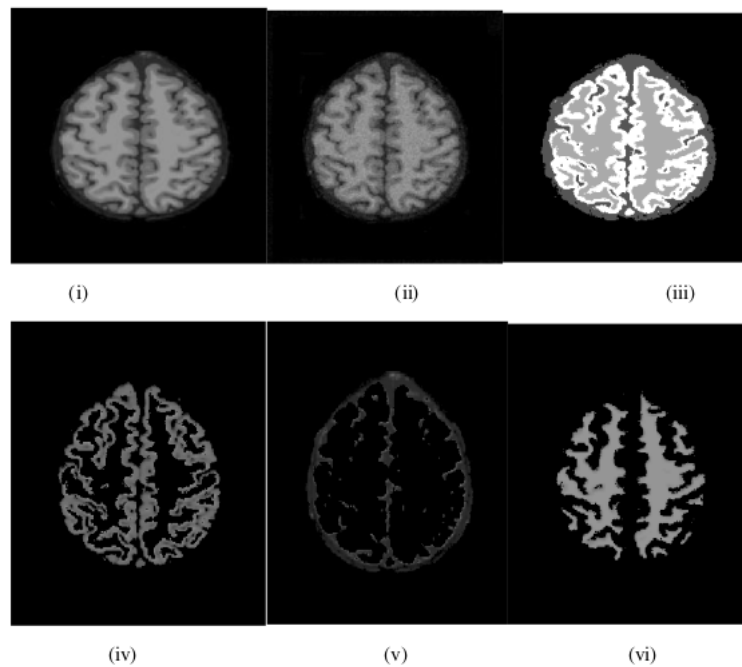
(i) MRI T1-126, (ii) MRI with 5% noise, (iii) MRI segmented using ACO-FCM, (iv) MRI with Gray, (v) CSF, (vi) MRI with White
